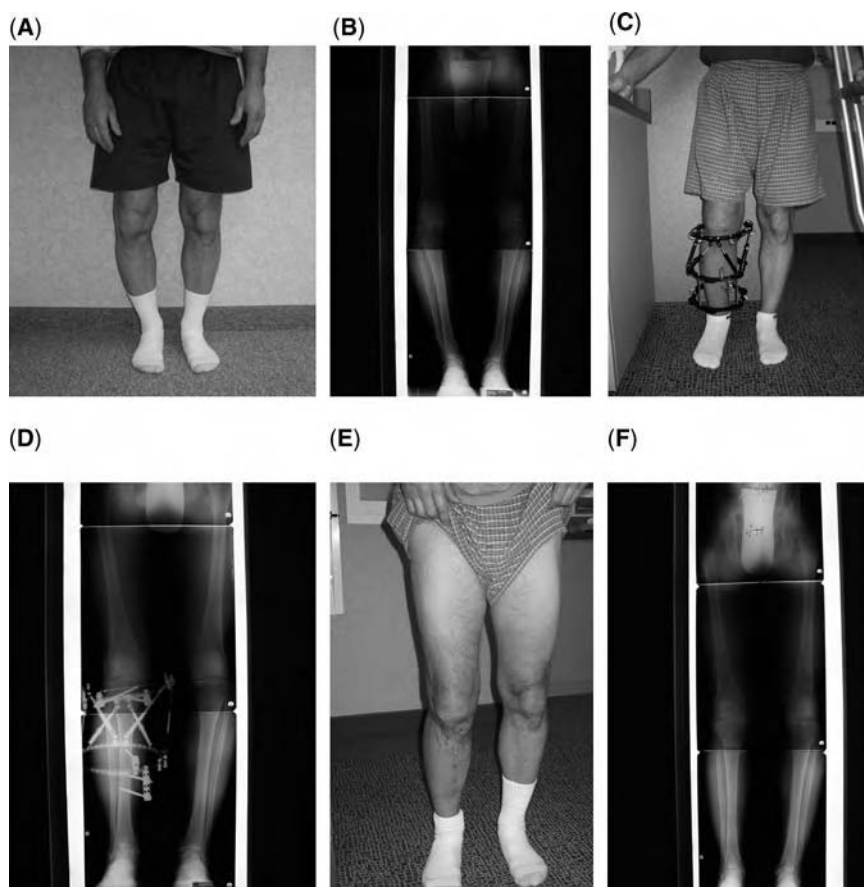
(A) Right varus knee, pre-op. (B) Standing X-ray, pre-op. (C) Hexapod frame with third distal ring for HTO with external fixation. (D) Standing X-ray, after correction of deformity. (E) Outcome after frame removal. (F) Standing X-ray after frame removal.
